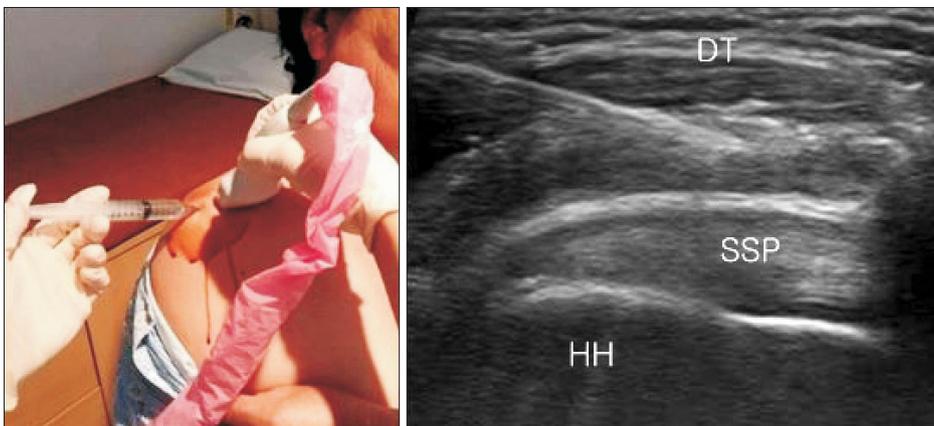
Ultrasound Guided Impingement Test.
